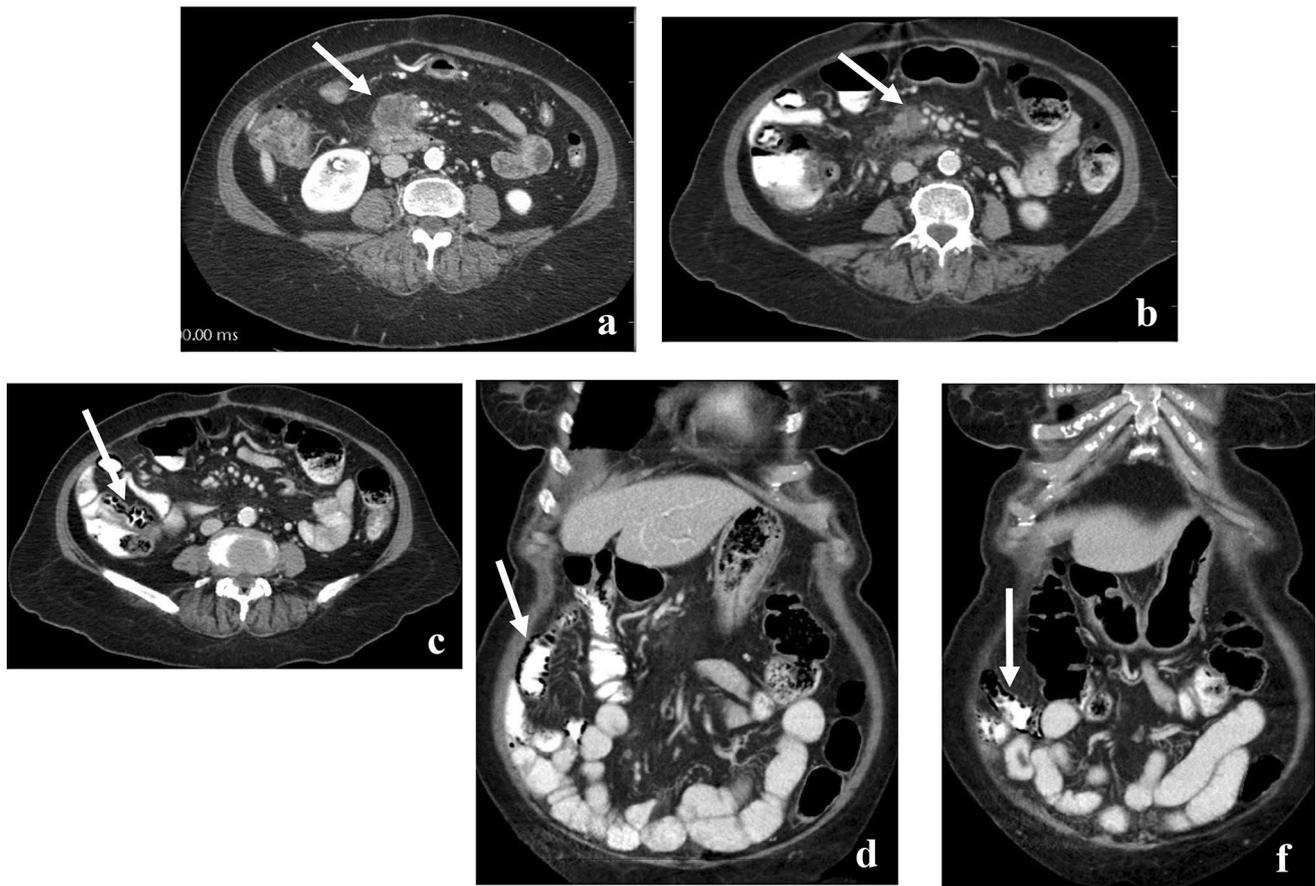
A 73-year-old male with malignant neoplasm of the pancreas. Baseline contrast-enhanced axial CT image shows a heterogeneous mass in the uncinus process of the pancreas (arrow in a). Follow-up contrast-enhanced axial CT image after initiation of fluorouracil/oxaliplatin shows interval decrease in size of the pancreatic mass (arrow in b). CT images also demonstrate incidental findings of new
